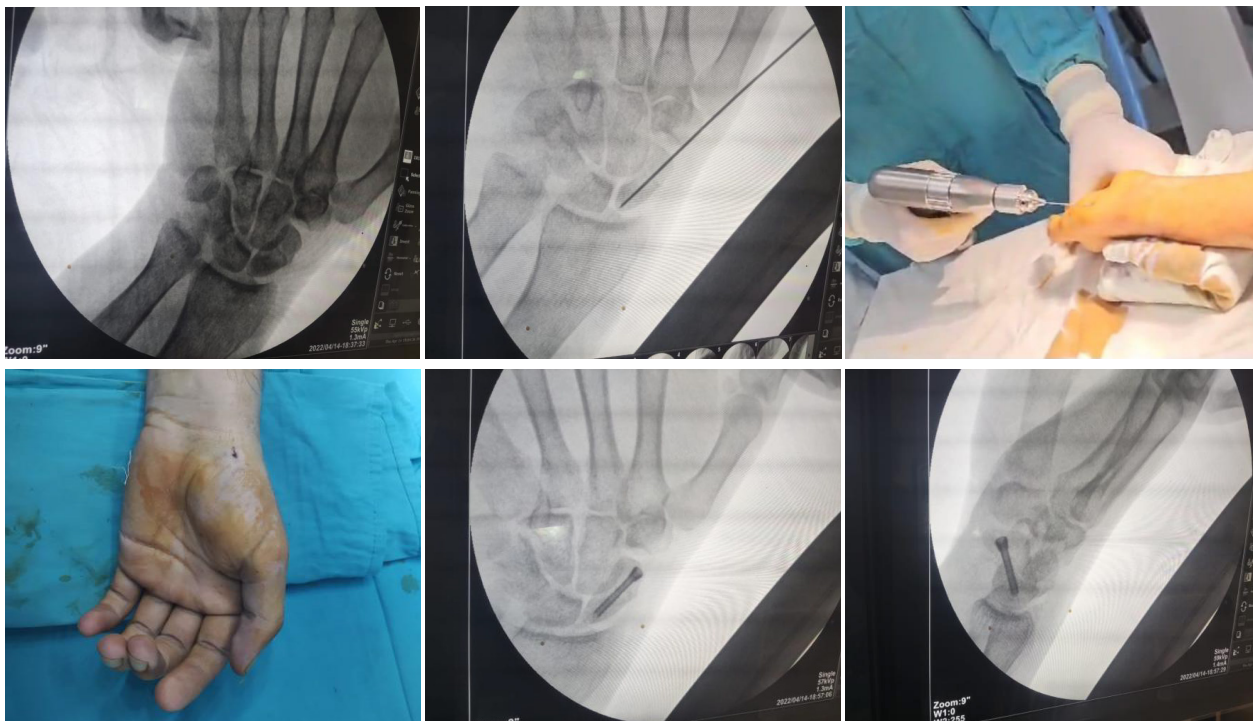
(A) shows pre-operative x-rays of the fractured scaphoid, (B) intra-operative guide wire placement fluoroscopic view, (C) intra-operative, (D & E) post-operative AP and lateral view and (F) post-operative wound size.
